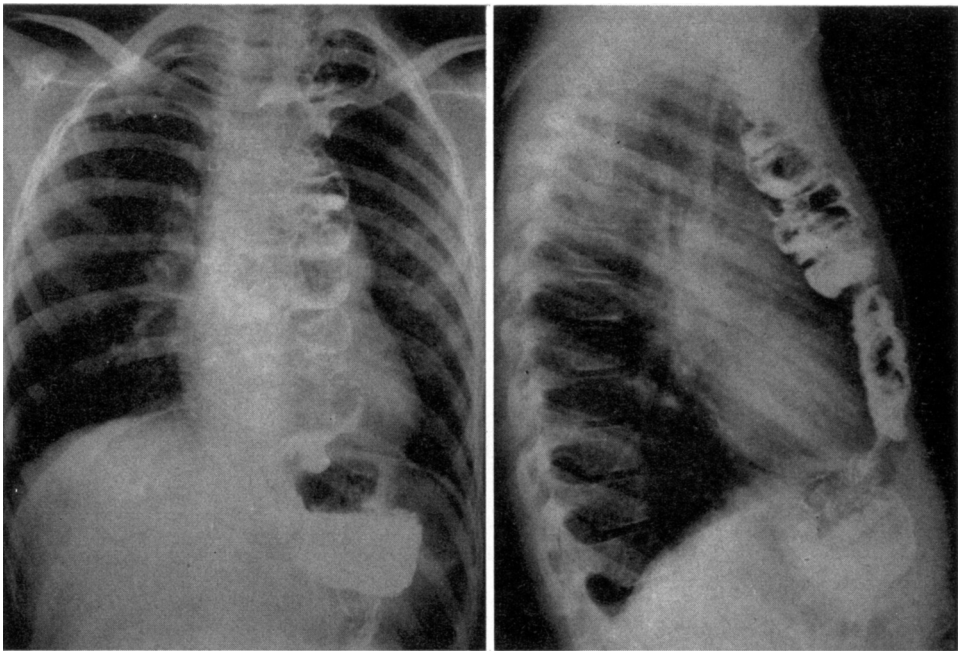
Roentgenograms of right colon transplant (R. B., Case 86). The cologastric anastomosis has been placed close to the cardioesophageal junction.
